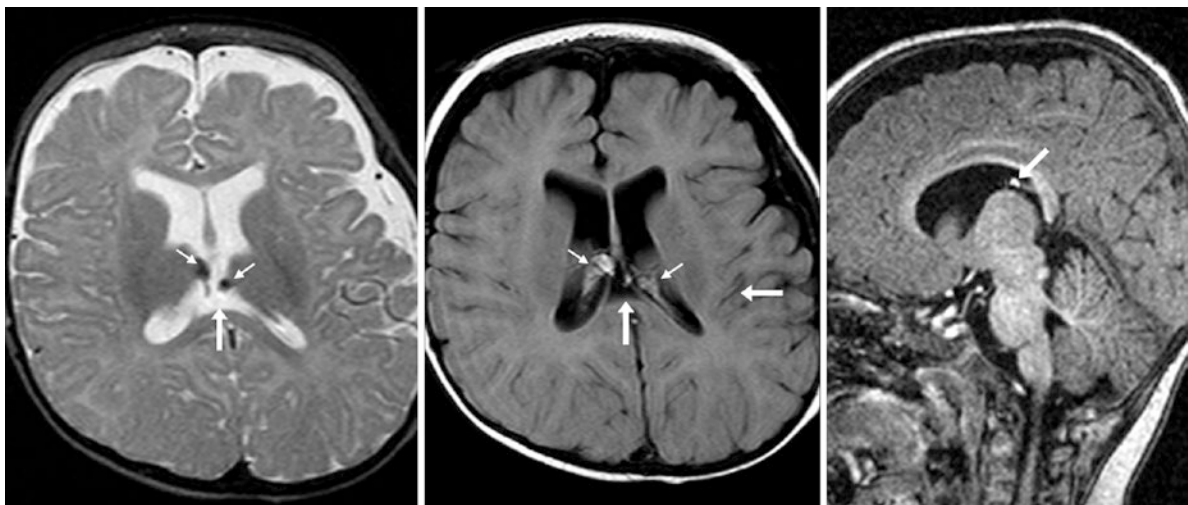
A 5 month old with a CVI (arrows) as well as choroid plexus lipomas (tiny arrows) on MRI. Choroid plexus lipomas are often associated with callosal/pericallosal (interhemispheric) lipomas, which may be associated with callosal dysgenesis (not seen here). They also have T1-bright, T2-dark, and DWI-dark signal, distinguishing them from normal xanthogranulomas. Xanthogranulomas are more common in the elderly and are less frequent in children
